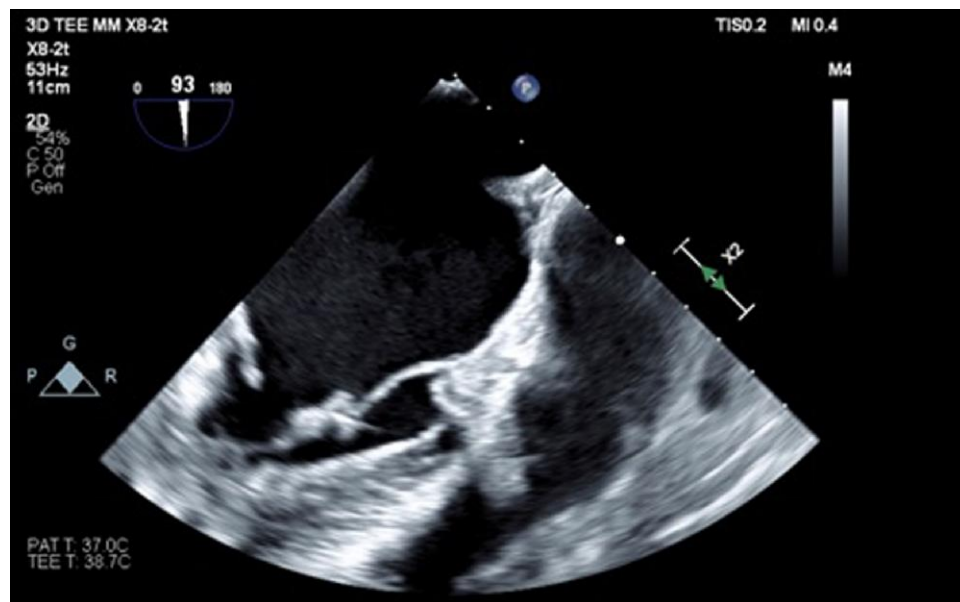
Echocardiogram—posterior leaflet detachment.
